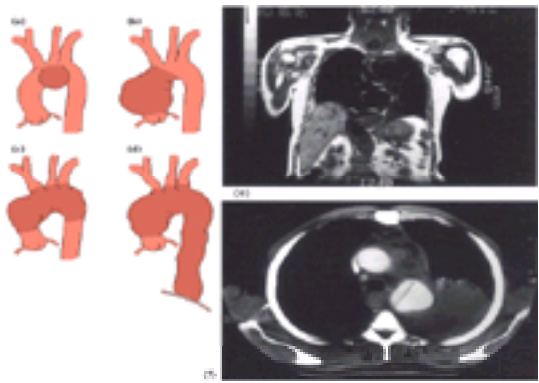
Aneurysms of the aortic arch: (a) saccular; (b) atheromatous ascending aneurysm extending into the arch; (c) atheromatous arch aneurysm; (d) chronic type A dissection; (e) MRI scan of atheromatous arch aneurysm; (f) rupture of the aortic arch in chronic type B dissection.
